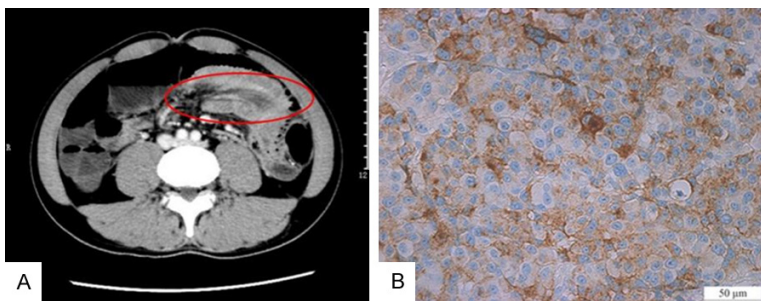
The enhanced Computed tomography of total abdomen (A) presented with jejuna intussusceptions (oval). And the mass of jejunum (B) showed positive immunoreactivity for human melanoma black 45 (HMB45) ($\times 400$).
